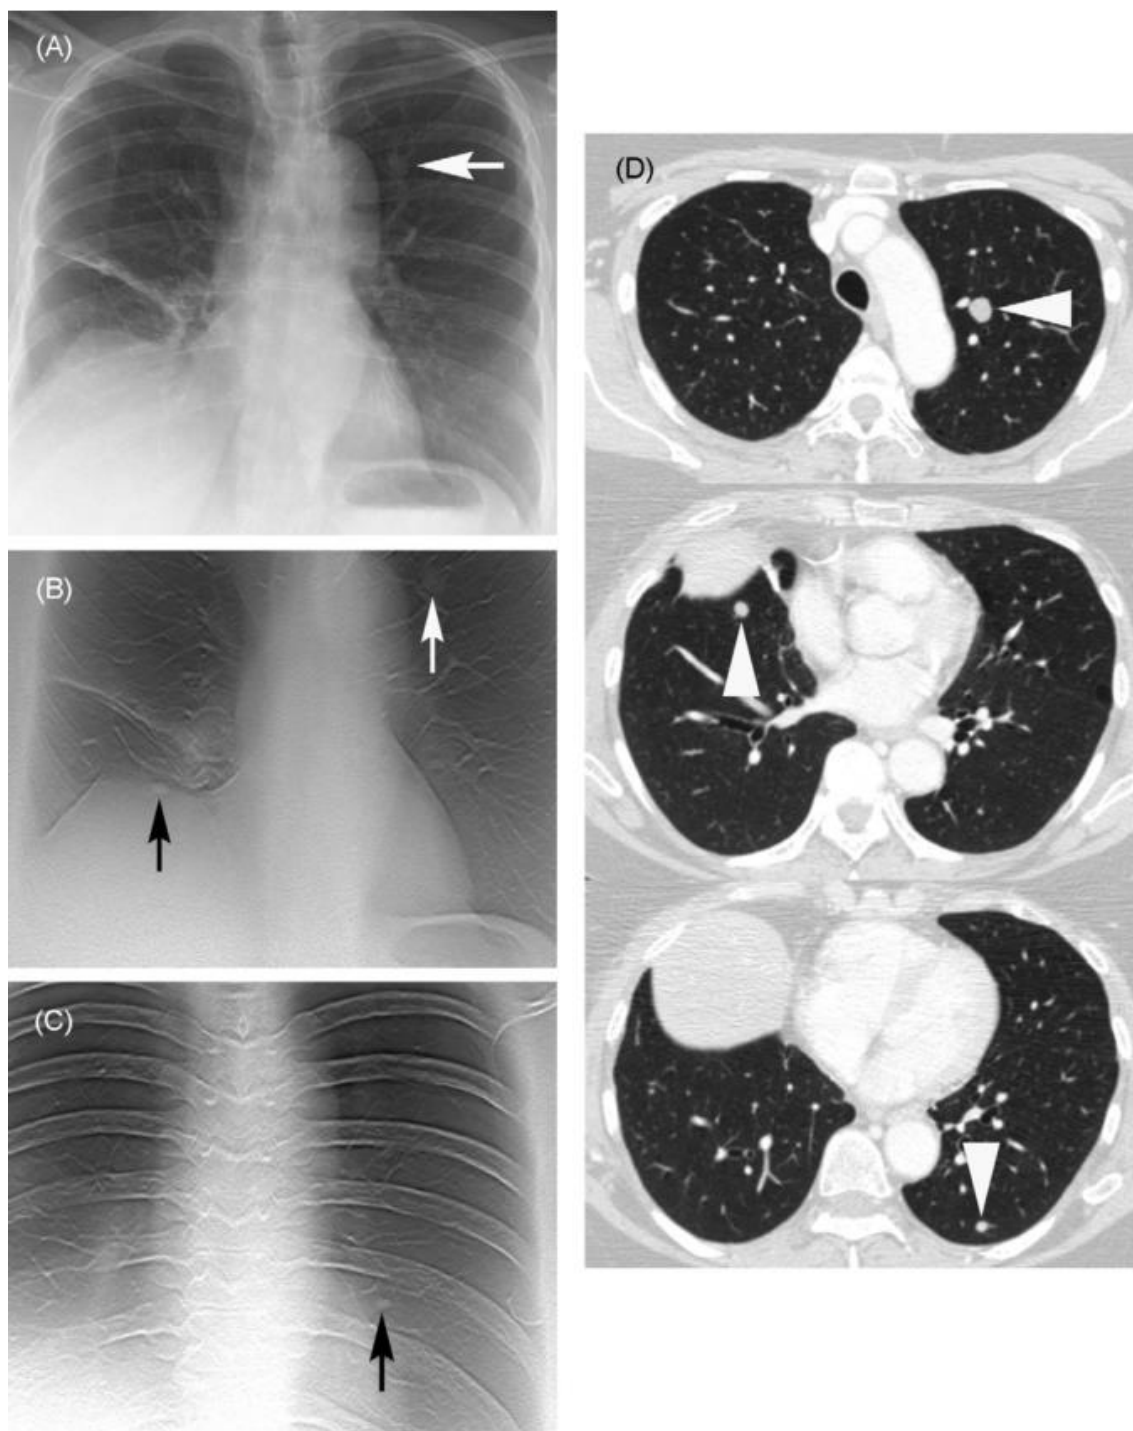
Patient with pulmonary nodules imaged by (A) chest radiography, (B)-(C) digital chest tomosynthesis, (D) CT.[40]
